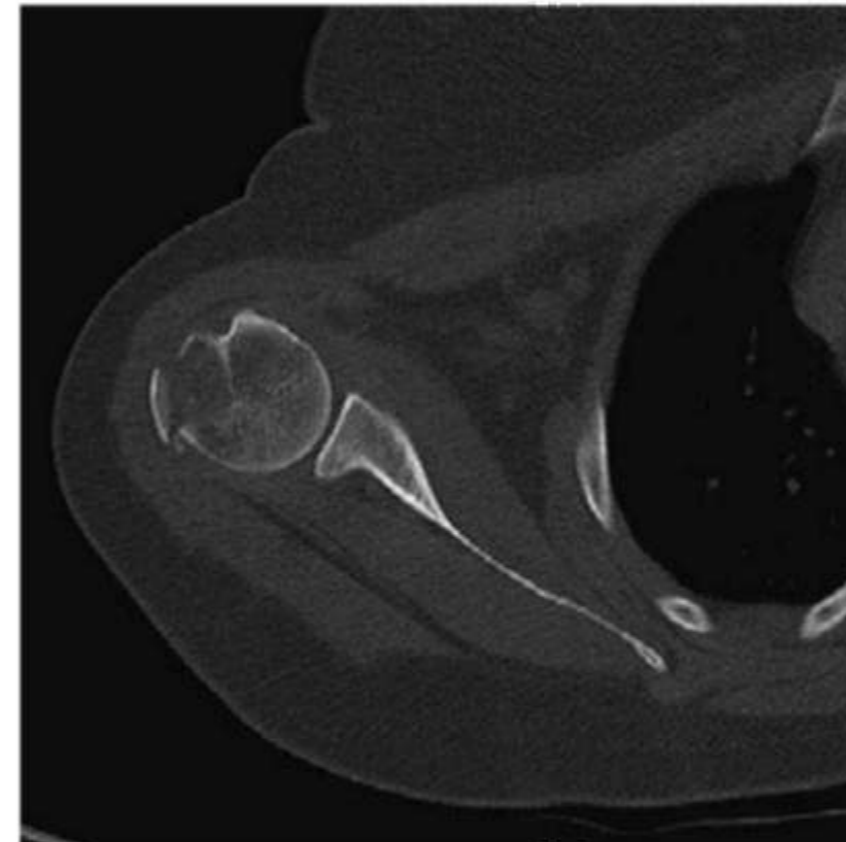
CT images right shoulder.
